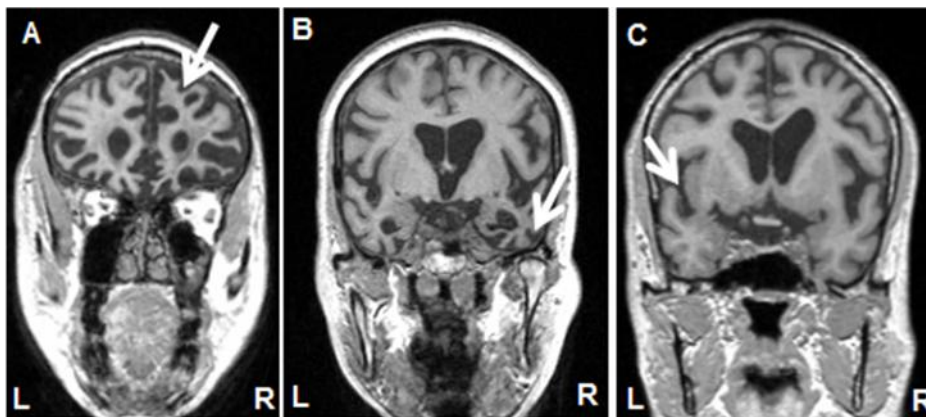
Structural MRI scans of typical FTD variants.
